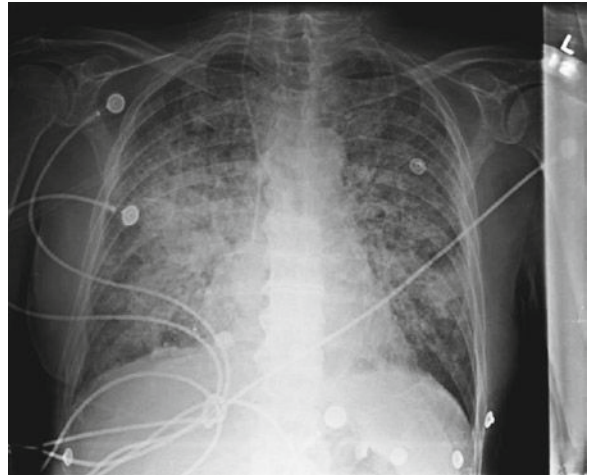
Patients with hematologic malignancies and CMV pneumonia frequently develop superimposed infections. Chest X-ray of a 72-year-old patient with chronic lymphocytic leukemia developed CMV and *Stenotrophomonas maltophilia* pneumonia showing diffuse consolidation in both lungs
